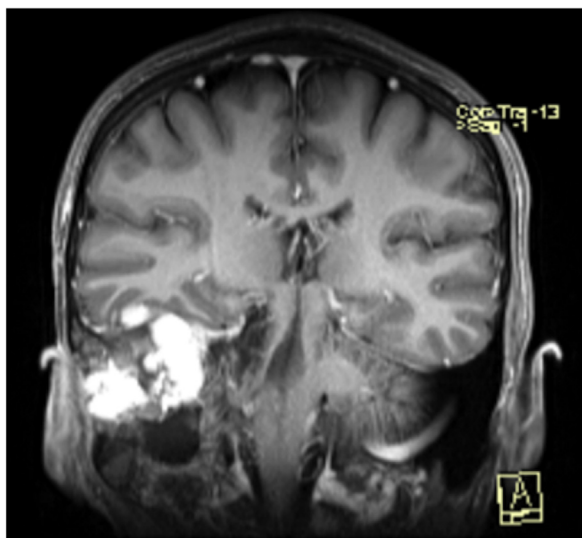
Coronal view of the MRI (T1-weighted with Gadolinium contrast) showing an encapsulated cystic mass compression the right temporal lobe and cerebellum.
